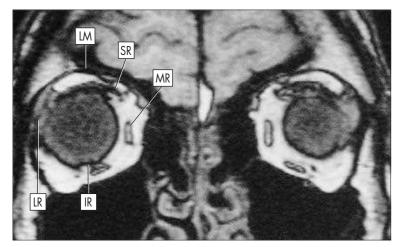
Coronal MRI Scan Through the Anterior Portion of the Orbit. The cut is similar to that seen in Fig. 12.3.4. *IR*, Inferior rectus; *LM*, levator muscle; *LR*, lateral rectus; *MR*, medial rectus; *SR*, superior rectus.
